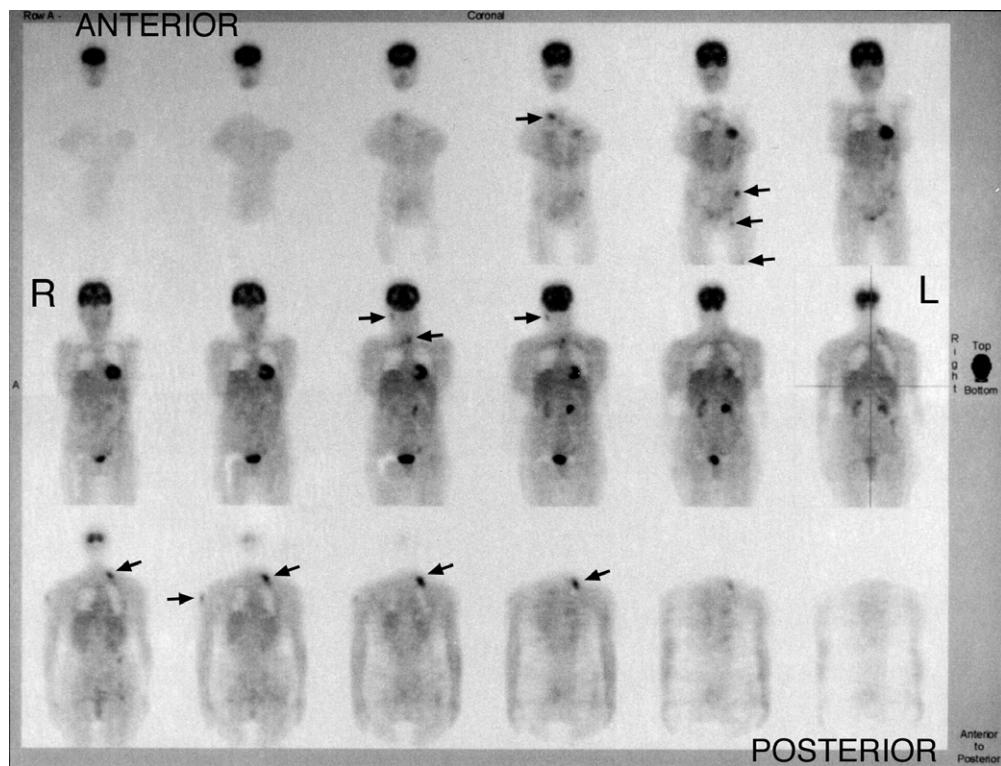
Coronal plane images from the pre-treatment F-18 FDG PET scan. The arrows indicate FDG activity above and below the diaphragm. R = right side of patient, L = left side of patient. A follow-up PET scan after 7 months of treatment was normal but a PET scan at 12 months showed a Grade I recurrence.
